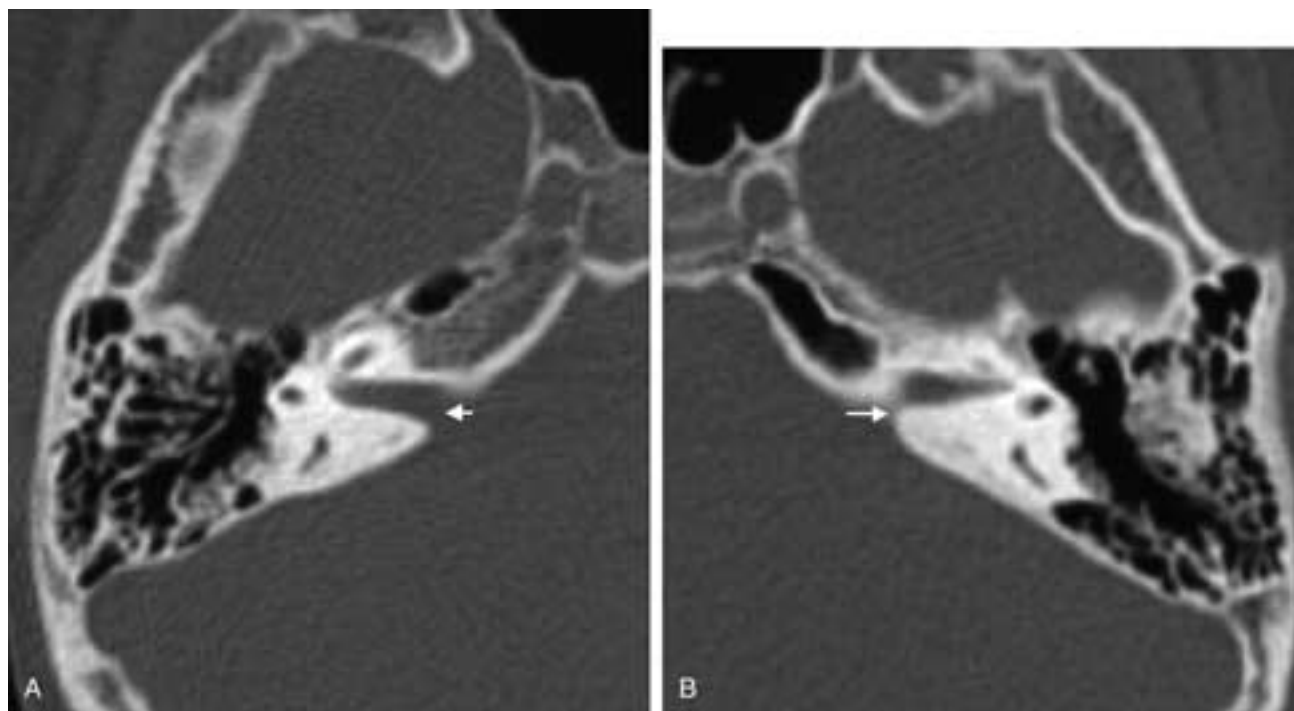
Stenosis of the IAC. A, Axial CT image showing a normal right-sided IAC (white arrow). B, Axial CT image showing a stenosed left-sided IAC (white arrow).
